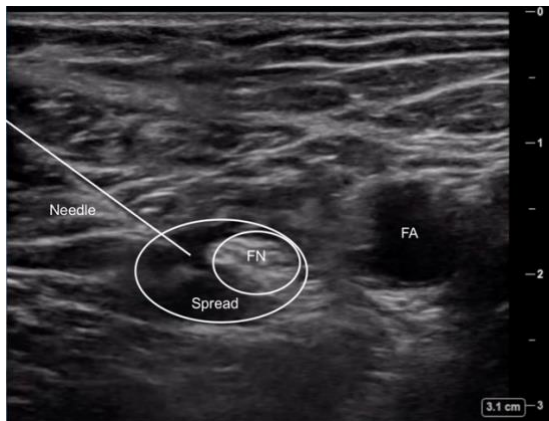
Femoral nerve block performed by ultrasound guidance. FN (Femoral nerve); FA (Femoral artery).
